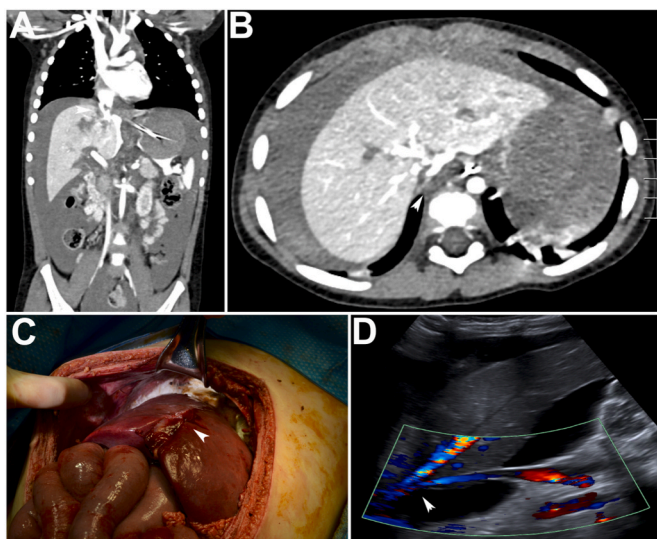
A-D. (A, B) Computed tomography at presentation shows disruption of the hepatic vein confluence with the inferior vena cava (arrow heads). Note extensive hemoperitoneum and retroperitoneal hematoma. (C) Intraoperative photograph at time of definitive abdominal closure ~36 hours after admission. Arrowhead denotes laceration along line of Cantlie. Final packing with dense oxidized regenerated cellulose. (D) Ultrasound one week after abdominal closure shows patency of hepatic vein confluence with inferior vena cava and no extravasation.
